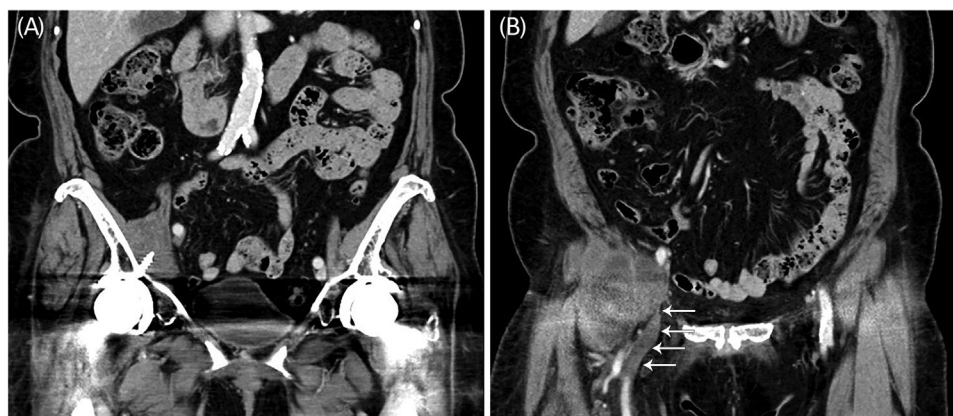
(A) A coronal computed tomography scan displayed fluid collection in the right iliopsoas muscle adjacent to the right hip joint. (B) Right femoral vein was compressed with distal venous filling defects (arrows).
